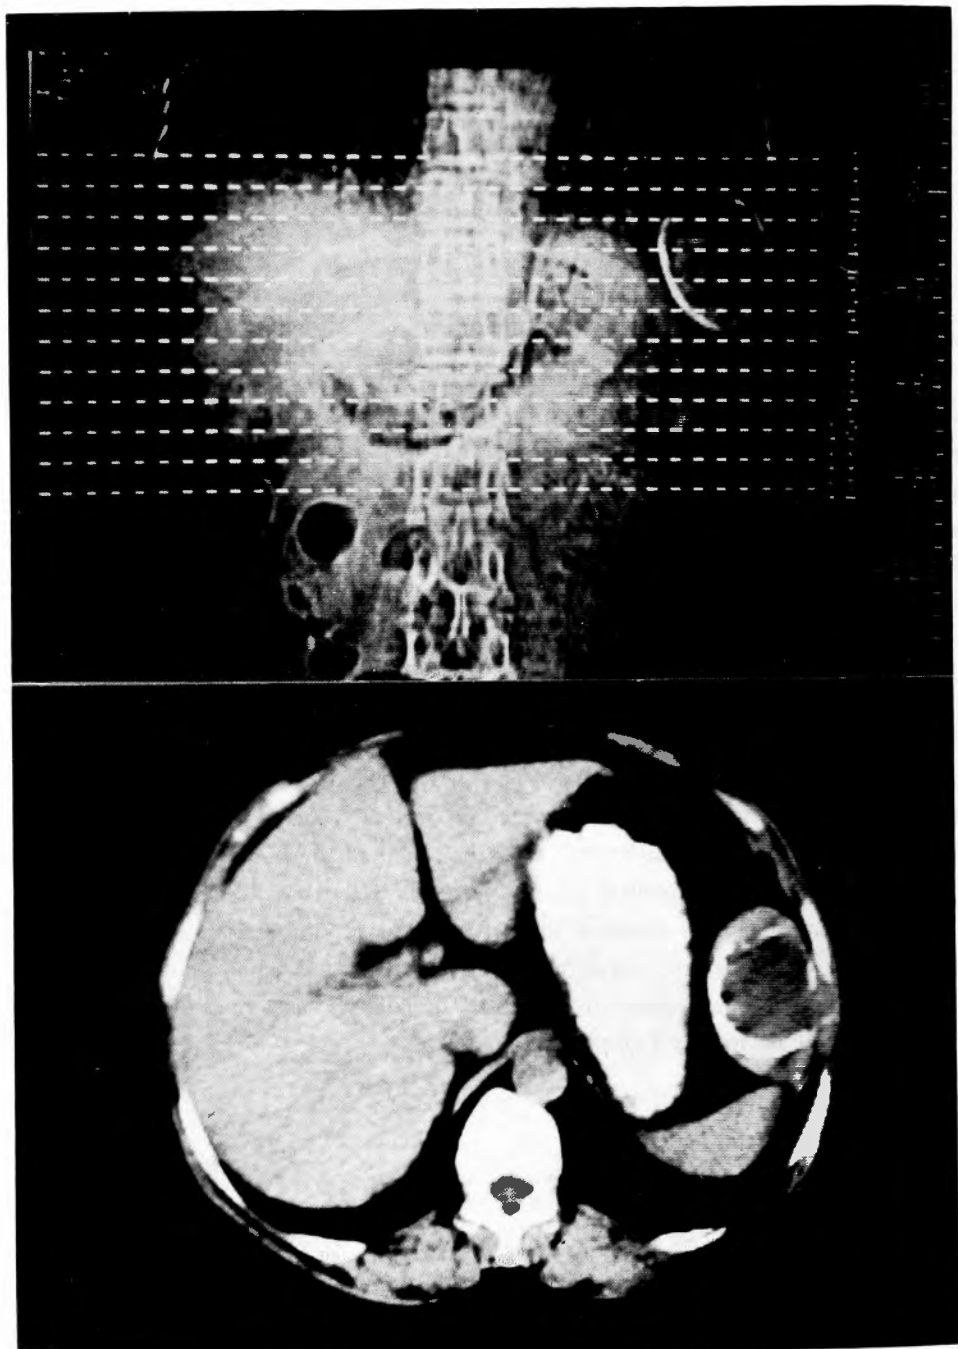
Computed tomogram. Seen at the portion corresponding to the lower pole of the spleen is a low density tumor shadow zoned by a high density area.
